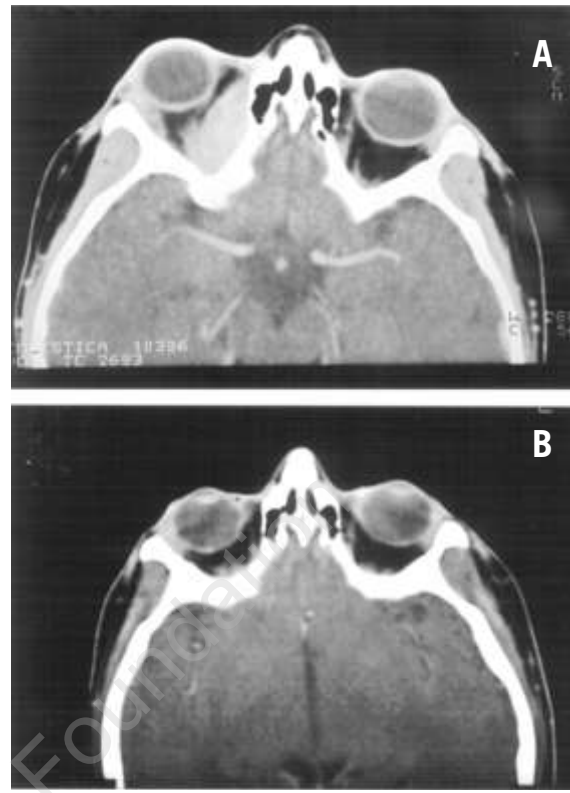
Case one: a) CT scan of the head at diagnosis showing the orbital mass; b) repeat CT scan five months after completion of radiotherapy documenting complete disappearance of the primitive lesion.
